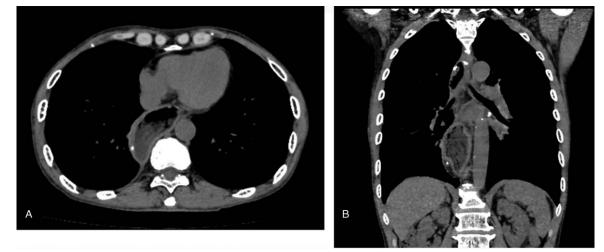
Computed tomography (CT) performed without evidence of recurrence or metastasis in the 24 months follow-up. CT = computed tomography.
